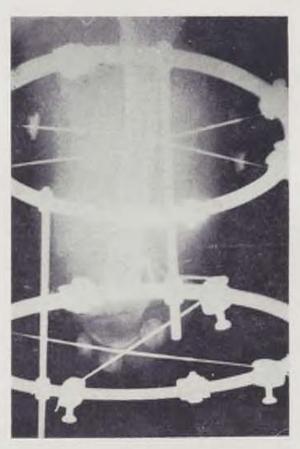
The same observation. Stump of the thigh after application of Ilizarov's apparauts (X-ray picture)
